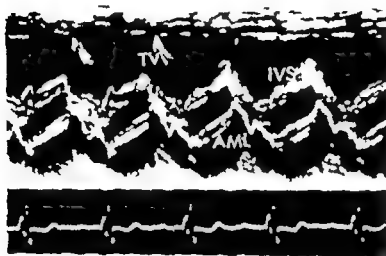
Echocardiogram in the mitral beam direction. The beam passes from the anterior mitral leaflet (AML) to the posterior wall of the left atrium. A dilated right ventricle and a paradoxical motion of the interventricular septum (IVS) are characteristic of right ventricular volume overload. Note the presence of the tricuspid echoes (TV) the systolic multiple echoes of the mitral valve and the prolonged mitral-septal apposition in diastole.
